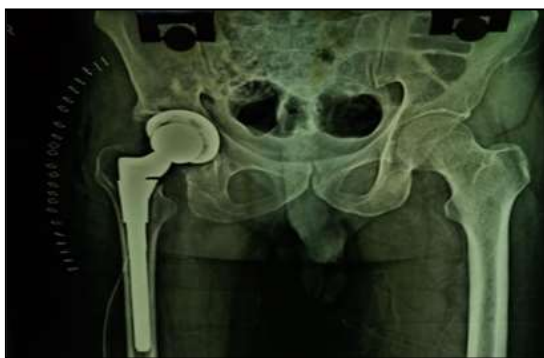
CASE 1- post op xray showing perfect hi centre and adequate medial wall with no bone graft
